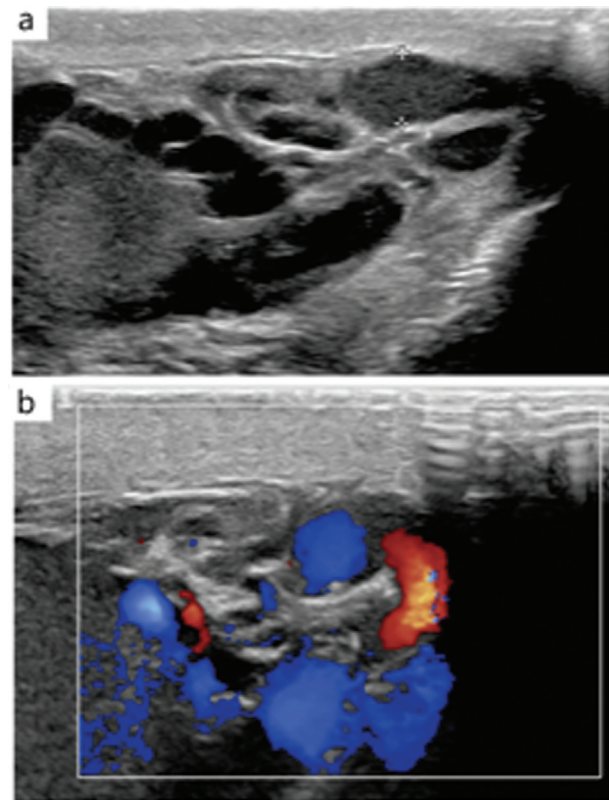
A 21-year-old male being evaluated for left varicocele. (a) Multiple serpiginous hypoechoic and anechoic vessels measuring up to 6 mm in diameter (calipers). (b) Color Doppler ultrasound demonstrating patent flow through the anechoic vessels.
